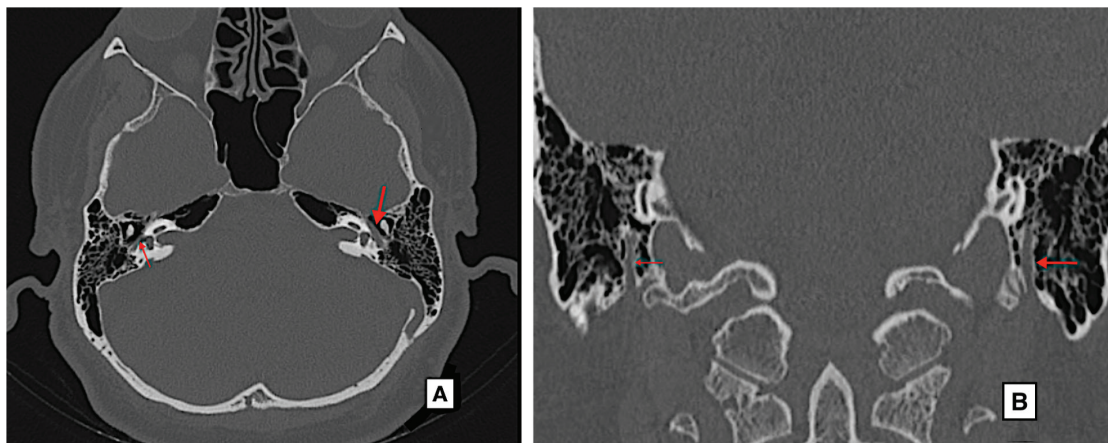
(A) CT, thin slice, bone reconstruction algorithm and window, axial image: Left facial nerve tympanic segment (large arrow) is wider than the right (small arrow). (B) CT, thin slice, bone reconstruction algorithm and window, coronal image: Left facial nerve mastoid segment (large arrow) is wider than the right (small arrow). CT, computed tomography.
